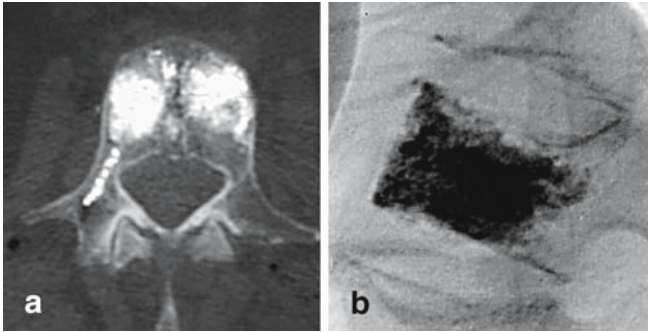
a Computed tomography scan showing cement filling after bilateral needle injection. b Lateral view radiographic control
